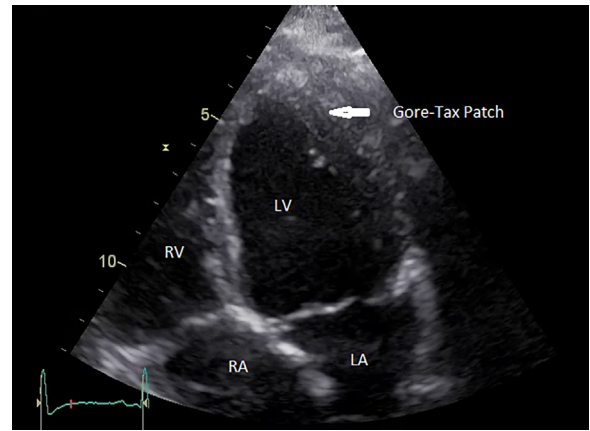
Apical four chamber view of the left ventricle after repair of the aneurysm using Gore-Tex patch repair.
